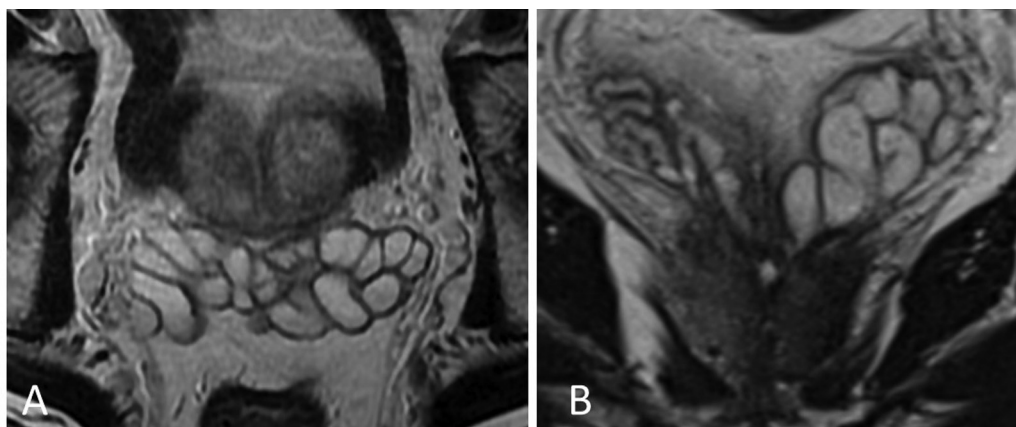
Normal seminal vesicles showing “cluster of grapes” appearance on T2-weighted image (T2-weighted image (T2WI) axial plane (A). Normal variant with asymmetry in T2 coronal plane (B).
